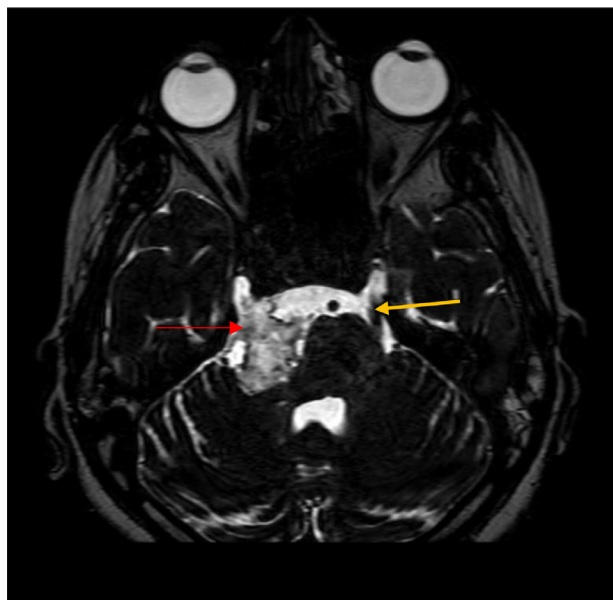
MRI Brain Axial T2 DRIVE sequence showing compressed right trigeminal nerve (red thin arrow) by the lesion (as described in the text) and normal left trigeminal nerve (yellow thin arrow).
